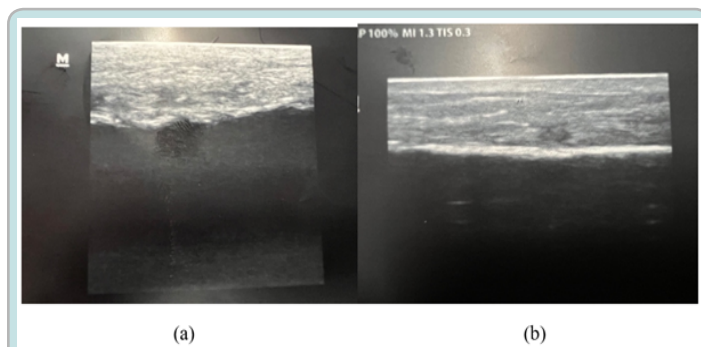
Ultrasound images captured before (a) and after (b) 6 weeks of the therapy.
